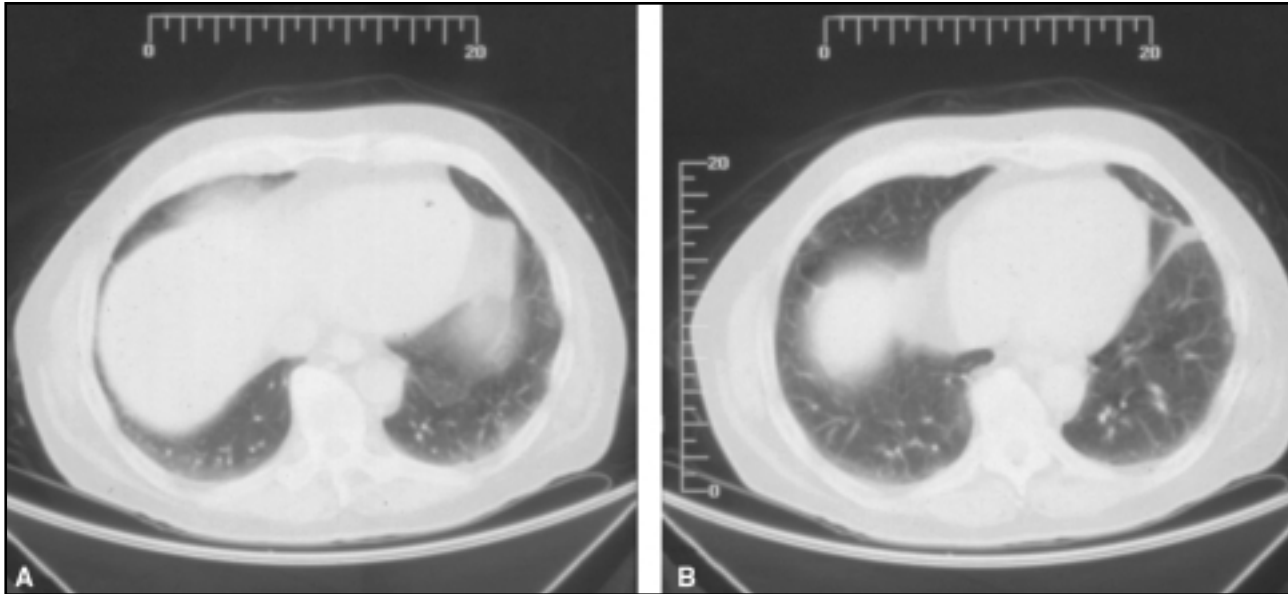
Computed tomography scans of the chest delineates bilateral lower-lobe 2- to 3-mm nodules from disseminated *M. bovis* infection.
